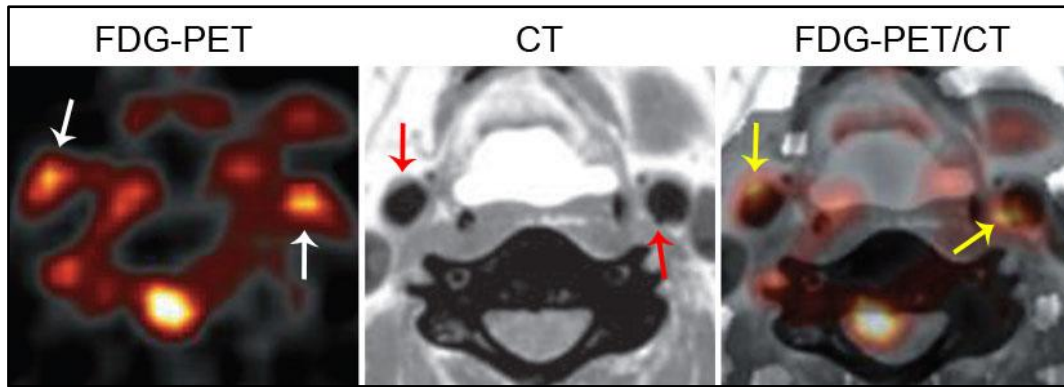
Carotid plaque inflammation detected by [^{18}F]-fluorodeoxyglucose PET (left), CT (middle) and FDG-PET/CT (right) (adapted by Kai, 2010)
